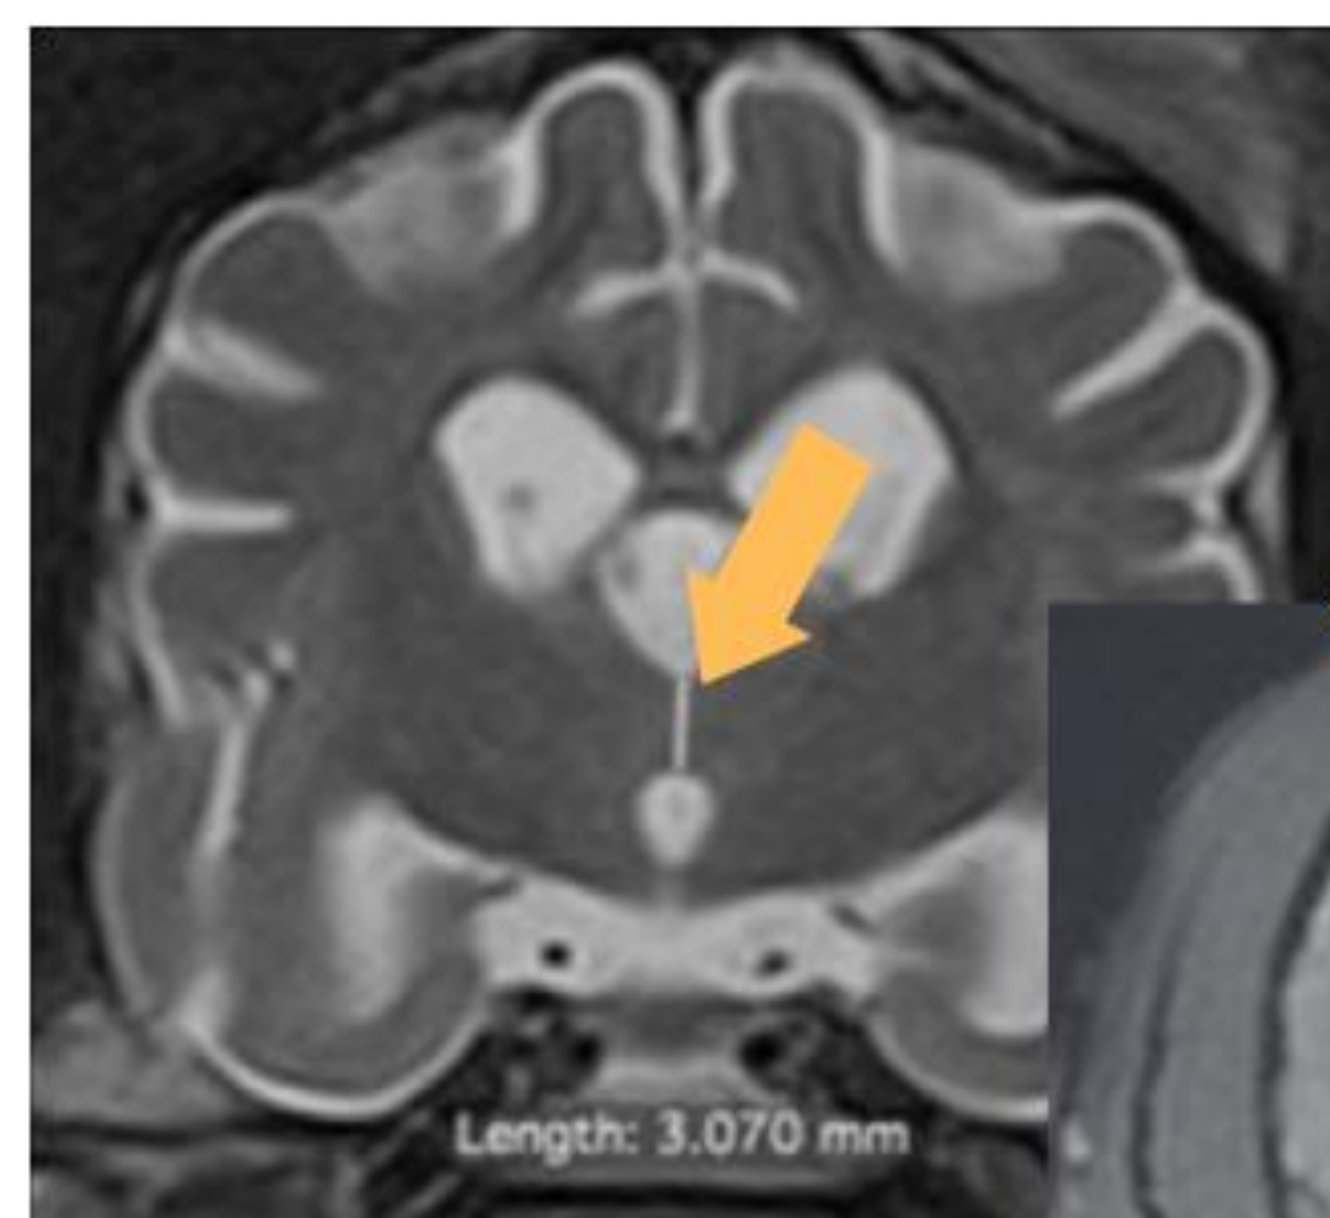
MRI evidencing the reduction of the interthalamic adhesion's size (Dewey *et al.*, 2019).
